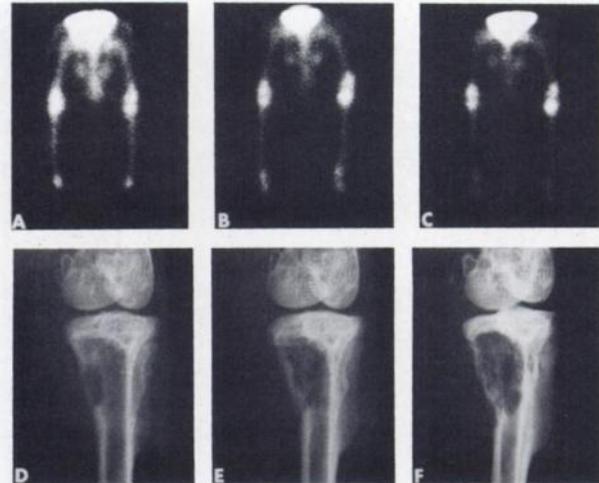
Undifferentiated osteosarcoma (fibrous spindle-cell type) developing in left hind leg after irradiation with 4650 rad fractionated over 3 wk. TcPPi images at 6 (A), 9.5 (B), and 12 (C) mo after irradiation and radiographs at 6 (D), 9 (E), and 12 (F) mo. Tumor first seen on radiographs at 6 mo (D) in posteromedial aspect of proximal tibia as radiolucent lesion with minimally sclerotic margin, and subsequently on scintigrams at 9.5 mo (B) as moderately elevated activity in proximal tibia. Progression of tumor growth evident on later radiographs; little change seen on later TcPPi images.
